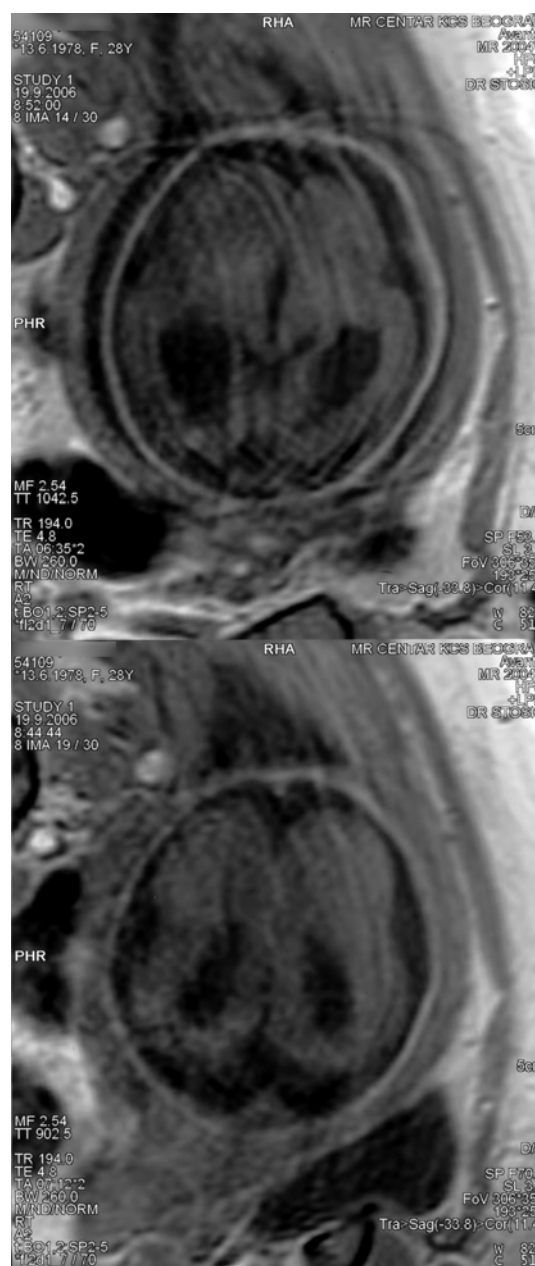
Fetal magnetic resonance imaging of the brain shows that the gyral pattern is smoother than the expected third-trimester configuration, suggesting lissencephaly.
